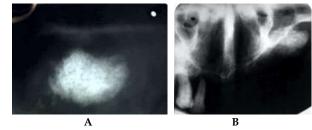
(a)Intraoral periapical radiograph and Occlusal radiograph. (b) of maxilla showing well defined radiopaque mass.
